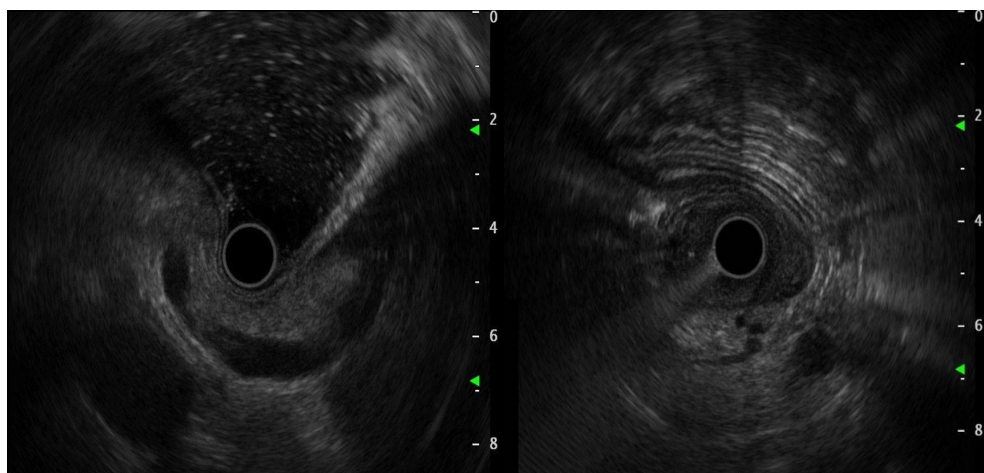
Ultrasound gastroscopy showing no dilatation of the common bile duct
